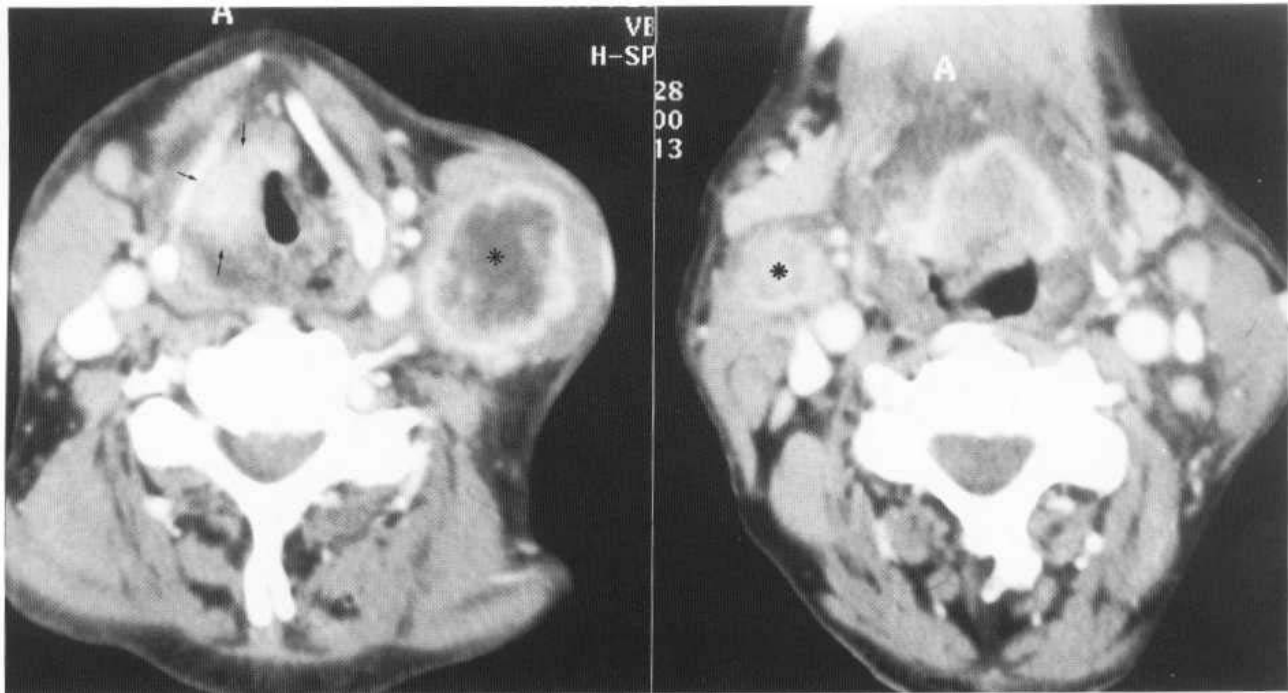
Two axial CT sections after contrast enhancement showing a supraglottic carcinoma (arrows) with bilateral neck nodes (asterisks).
